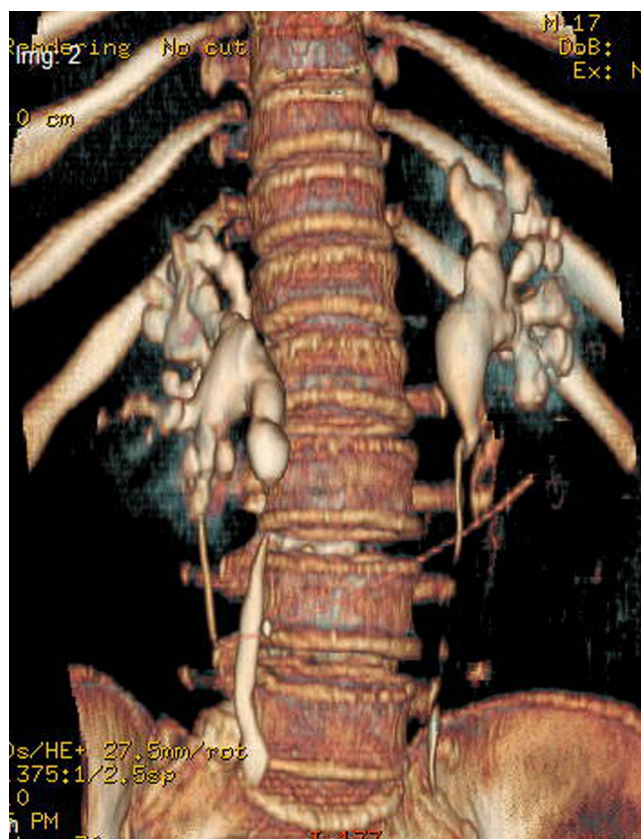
Abdominal CT. Reconstruction of staghorn calculi picture in both kidneys
